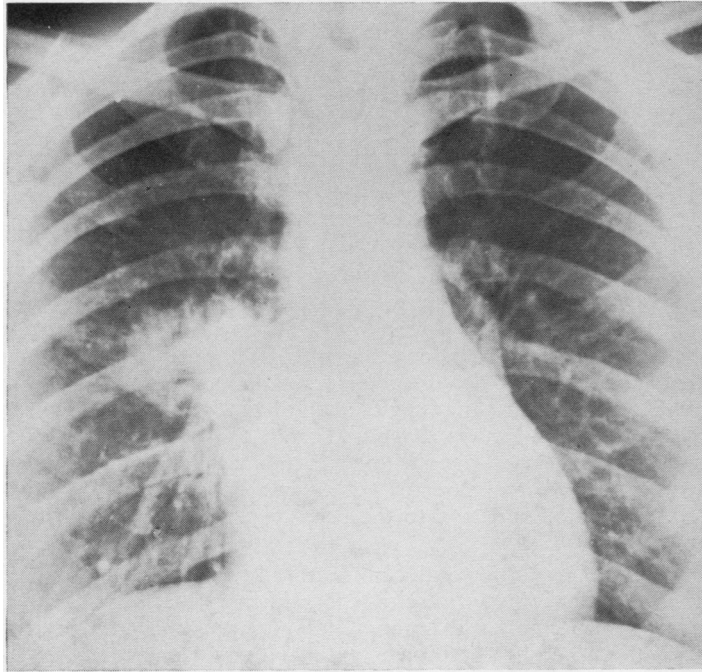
Chest radiograph showing a round, poorly defined shadow in the right hilum. Slightly increased pulmonary markings.*
